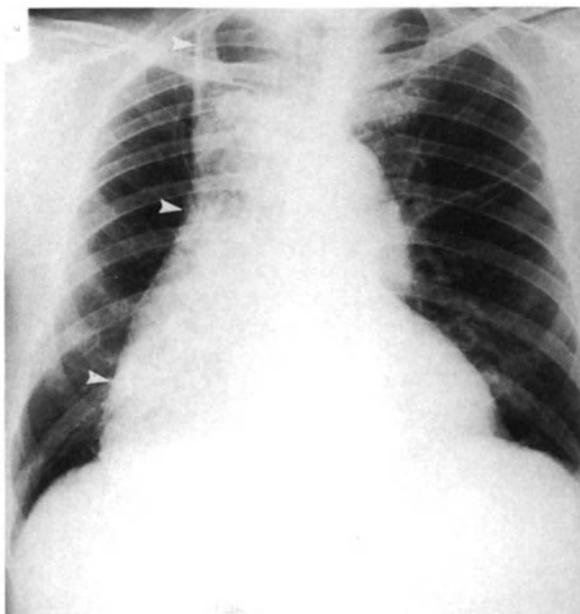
Mediastinal neurofibroma. A Chest radiograph in asymptomatic patient shows posterior mediastinal mass (arrowheads). B CT confirms the paraspinal location of the mass (arrowheads).
